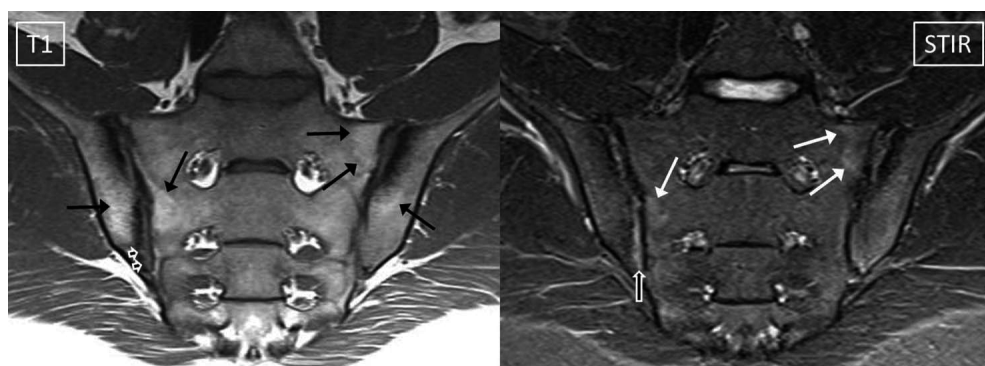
MRI sacroiliac (SI) joints—typical findings in non-radiographic axial spondyloarthritis (SpA) showing minimal inflammation and structural damage changes. MRI of SI joints in a 20-year-old male with inflammatory low back pain of more than 3 months duration. C-reactive protein was normal at the time of the MRI scan and HLA-B27 was positive. Pelvic radiograph was suspicious for SpA but did not meet the definition for a positive radiograph according to the modified New York criteria—right SI joint grade 2 and left SI joint grade 0. The short tau inversion recovery (STIR) sequence shows subtle increased signal (white arrows) in the subchondral bone of the right and left sacral alae suspicious for bone marrow oedema (BMO). However, the lesions are faint and heterogeneous and the right sacral lesion was only visible on one slice. If no other findings were present, it would be difficult to decide whether the BMO changes alone do or do not meet the criteria for a positive MRI. However, multiple other abnormalities are present on the MRI that materially influence the decision. On the T1-weighted sequence, subtle articular surface erosion is definitely seen at the caudal end of the right ilium (arrowheads); subtle foci of fat metaplasia are seen in all four bones (black arrows); and bilateral iliac subchondral sclerosis is present. Additionally, on the STIR sequence, abnormal increased signal overlying the area of articular surface erosion is typical for inflammation in the cartilage/joint space (compound arrow). Each finding individually is non-specific; however, in combination the appearance and distribution of all the findings are typical for inflammatory sacroiliitis. In conclusion, the MRI scan meets the Assessment in SpondyloArthritis International Society (ASAS) definition for a positive MRI because (1) BMO on STIR is present; (2) the inflammation is located in a typical anatomical area (subchondral bone) and (3) the MRI appearance is highly suggestive of SpA—in this case, because the findings of BMO are supported by MRI findings of structural damage (erosion, fat metaplasia and sclerosis) that are typical in appearance and distribution for SpA.
